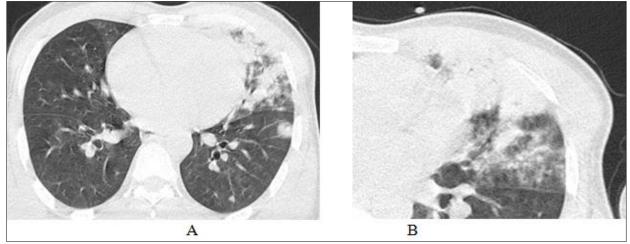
Early CT findings of invasive pulmonary aspergillosis. A, Multiple small inflammatory masses. B, Clusters of fluffy nodules
